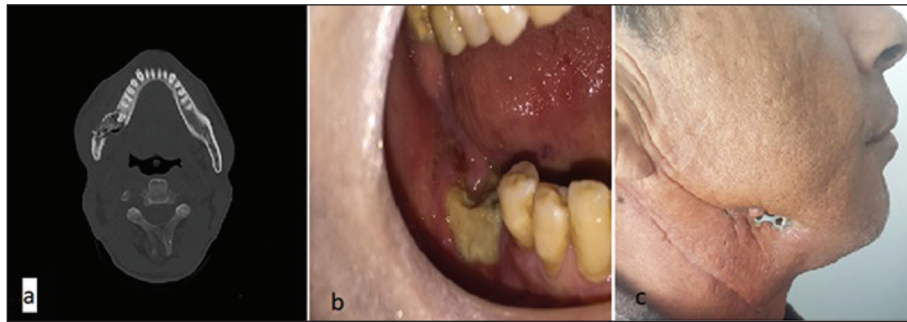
A 54 years old male patient with pathological fracture at angulus region of mandible secondary to osteoradionecrosis. Axial computed tomography shows irregular bone destruction and fracture line (a) Intraoral photo of necrotic bone (b) A complication of plate exposure following operation (c).
